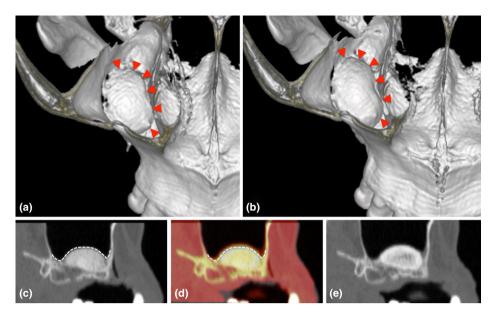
Radiographic analysis based on superimposition of computed tomographies immediately and 24 weeks after surgery. The augmented area could be observed on three-dimensionally reconstructed images (red arrowheads) at immediately (a) and 24 weeks (b) after surgery, and these could be superimposed by unchangeable structures, like zygomatic arch, nasal sptum, etc. After superimposition of reconstructed images, superimposed sectional images (d) can provide the dimensional changes from the time point immediately after surgery (c) and 24 weeks after the augmentation (e). Colorfully accentuated image: samples from 24-week observational period, dotted line: roof of the augmented area immediately after surgery.
